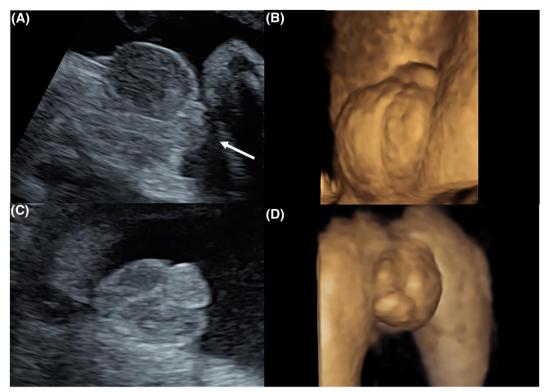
2D and 3D US of the genitalia in severe hypospadias in the third trimester. (A) 2D US in case 25 at 31 weeks of gestation demonstrating the ventrally curved and shortened phallus, blunt tip of phallus (arrow) in the sagittal plane. (B) 3D US surface rendered view in case 25 showing the scrotum in distal hypospadias and the ventral curvature of the shortened phallus. (C) 2D US in case 22 at 30 weeks of gestation demonstrating the shortened phallus interposed between the scrotal walls in the axial plane. (D) 3D US surface rendered view in case 22 showing the partial bifid scrotum in penoscrotal hypospadias and the ventral curvature of the shortened phallus. US, ultrasound
